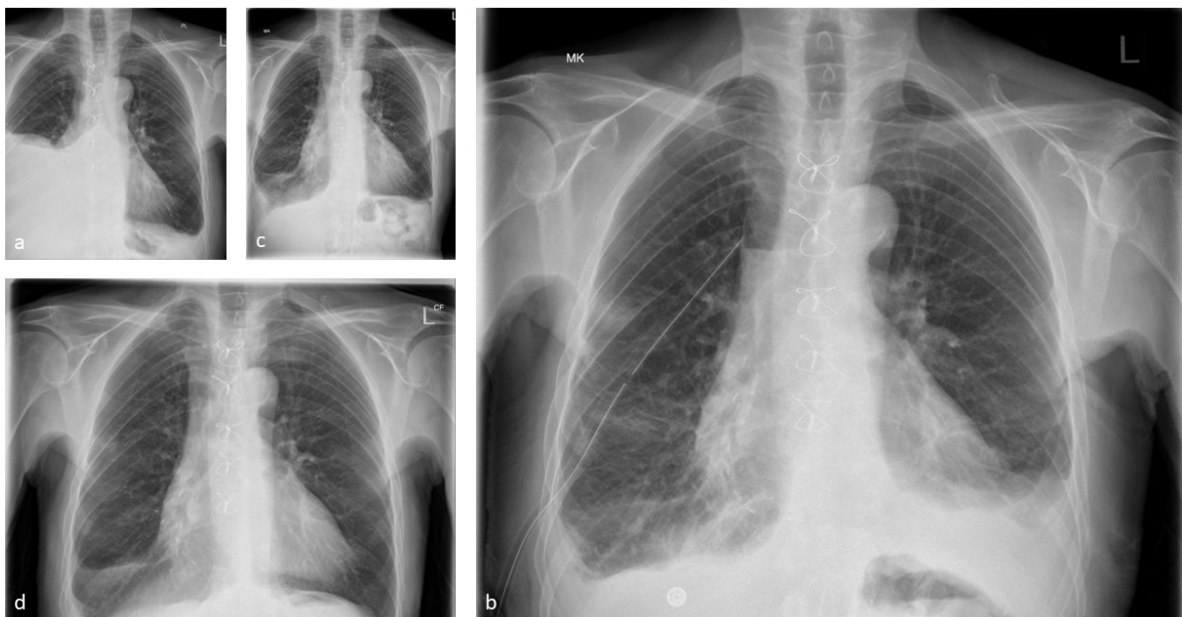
(a) Chest X-ray on Transfer to Tertiary Cardiothoracic Unit. (b) Chest X-ray after Chest Drain Insertion. (c) Chest Drain Post-drain Removal. (d) Chest Drain 10 Days after Discharge.
